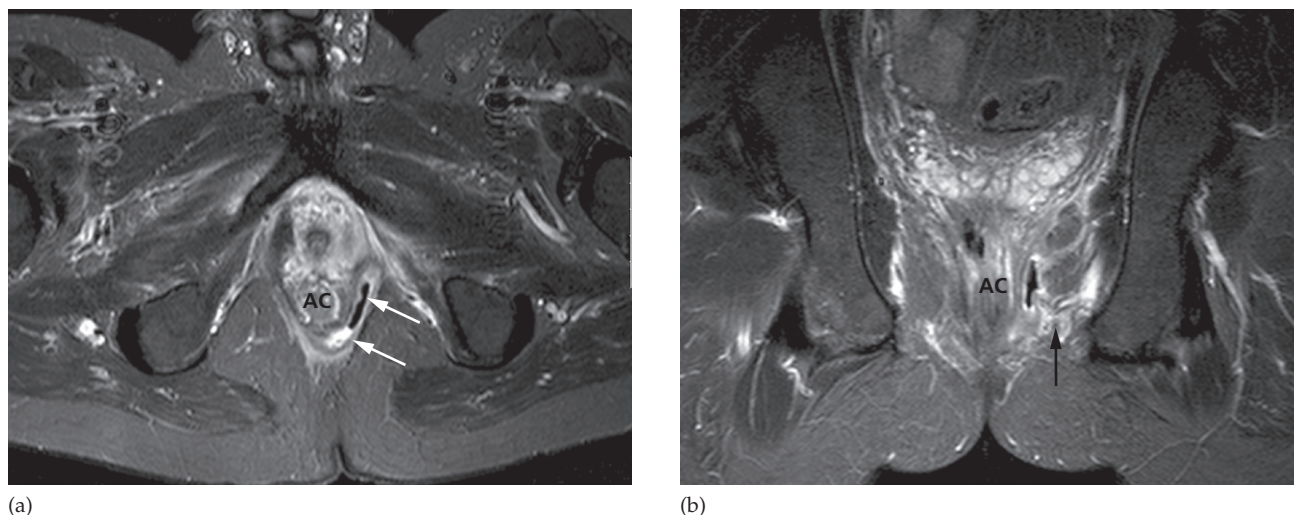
Perianal fistula in Crohn's disease on MRI. (a) Axial MRI using a specialized sequence which is T2-weighted with fat saturation (STIR sequence) demonstrating air and fluid within a cavity that runs in the left intersphincteric space, involving the external sphincter (arrows). (b) Coronal STIR demonstrating air within the fistula as well as bright inflammatory change in the ischiorectal fat (arrow). AC, anal canal.
